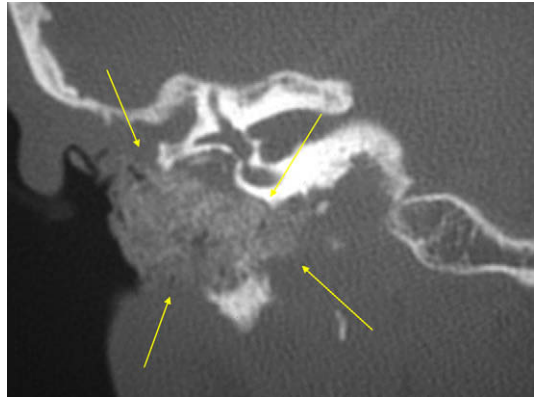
Coronal CT image shortly after surgery shows the appearance of absorbable gelatin sponge packing in the middle ear and mastoid (*material between arrows*).
